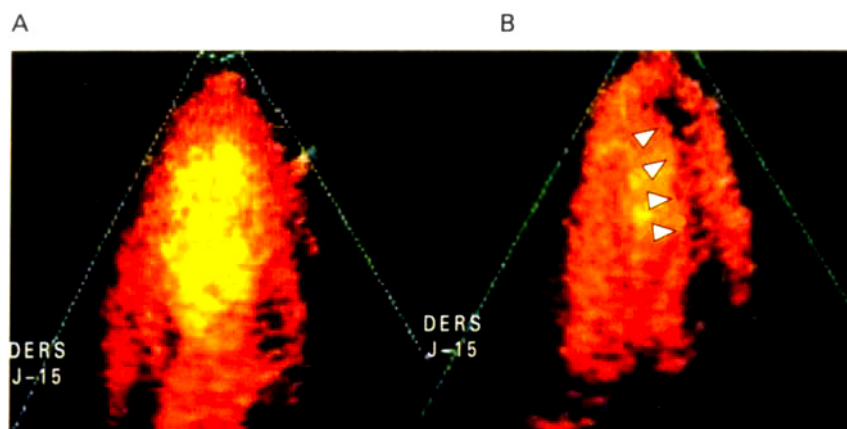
Contrast stress echocardiography: transthoracic two chamber view of the left ventricle at two different times during dobutamine stress echocardiography after intravenous injection of pentafluoropentane. (A) At rest: the intraventricular cavity is filled with contrast, and the ventricular walls are homogeneously perfused. (B) Under dobutamine perfusion, a lateral wall defect appears as black spots with no perfusion by contrast agent. (From Porter *et al.*,³³ with permission.)
